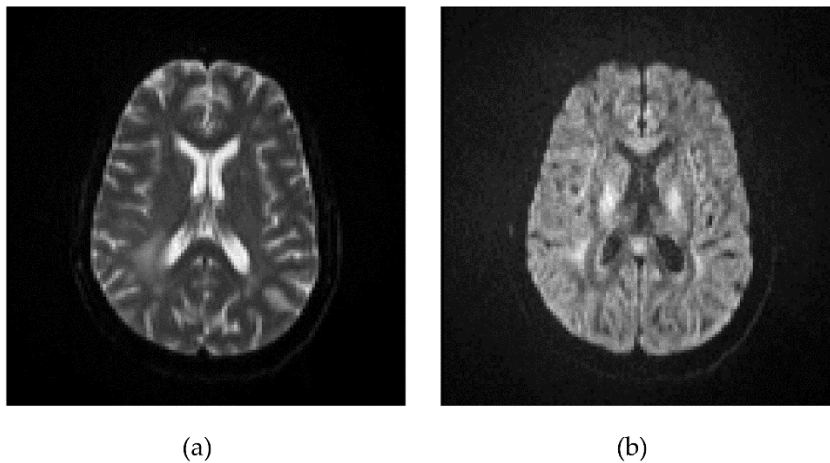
An example of diffusion weighted images. (a): Image without diffusion gradient. Noting that it is T2-weighted. (b): Image with diffusion gradient, b-value set at 1000 s/mm².
